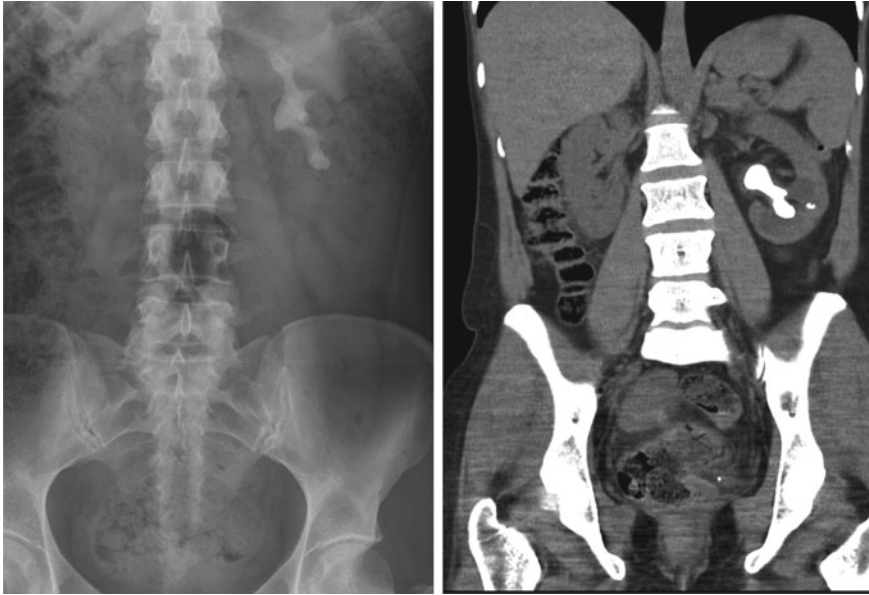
Comparison of respective images from plain abdominal X ray (left) and CT KUB (right) reconstruction, showing greater detail of lower pole calyceal anatomy for where puncture is planned, including additional fragment separate to main calculus which will also require extraction
